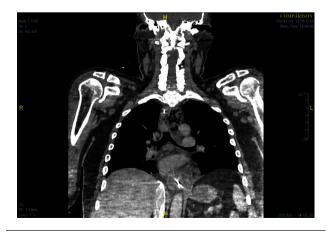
CT of the neck and thorax with contrast, coronal plane, performed 7 days following initial presentation, revealing a mediastinal collection measuring  $36\times34$  mm above the level of the aortic arch.
